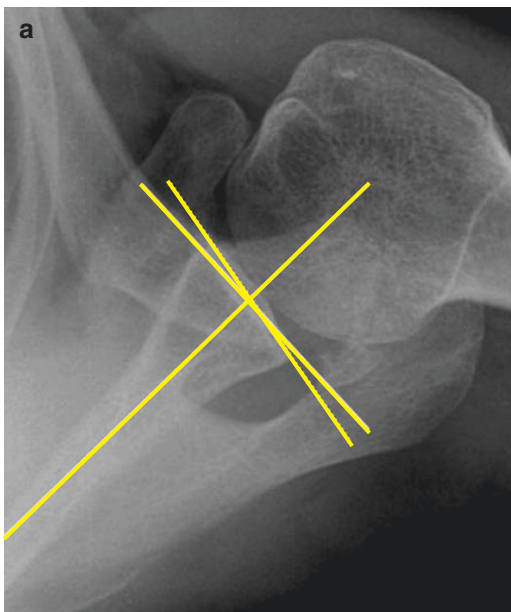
Glenoid version estimation: Radiographic
